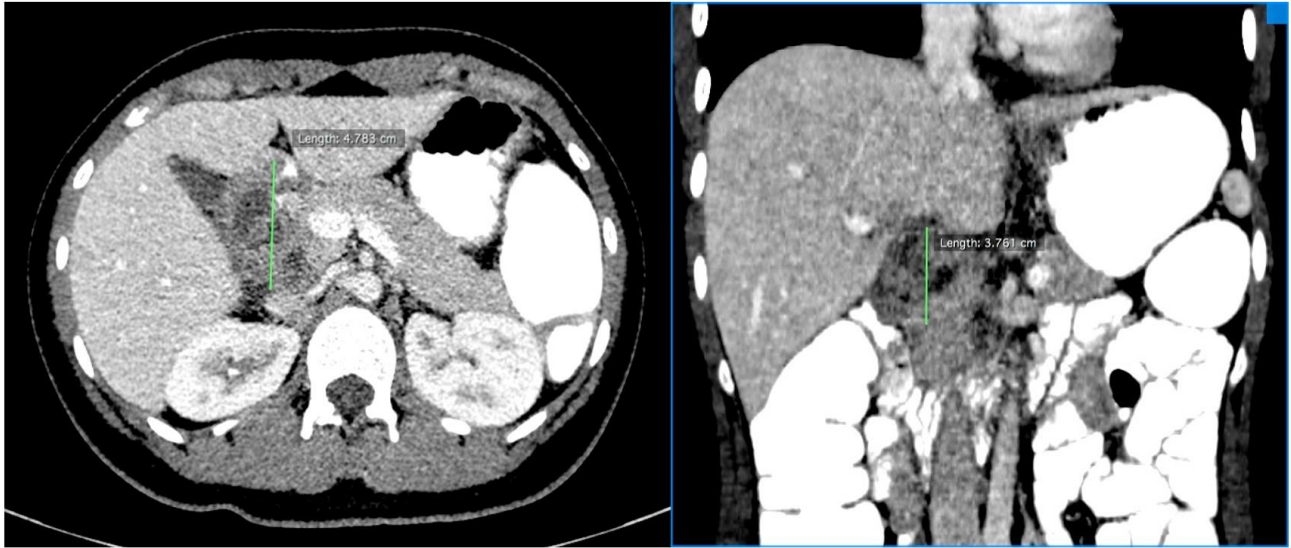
contrast-enhanced CT scan demonstrating an ill-defined enhancing heterogeneous enhancing mass measuring 5.1x3.6x4.0cm at the pancreatic head (green cursor)
